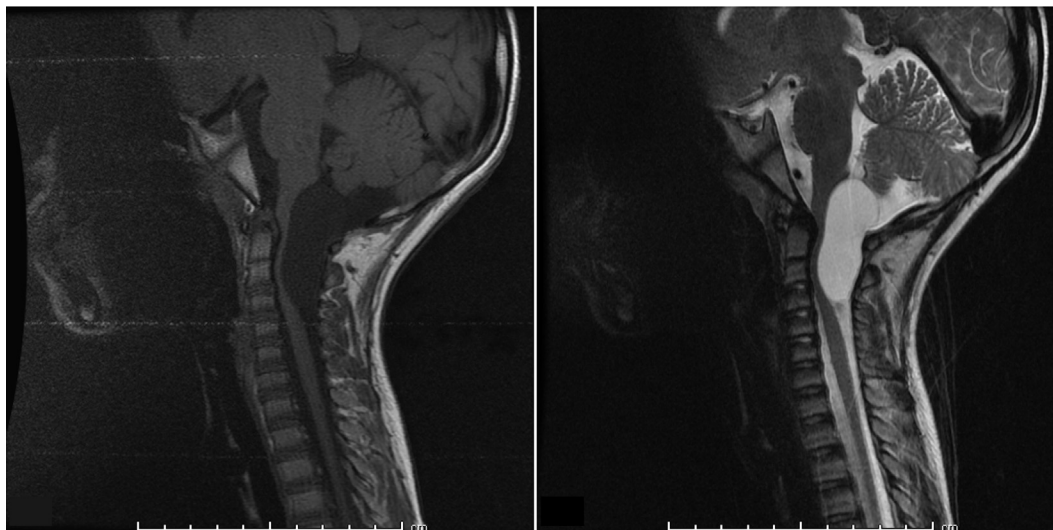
Sagittal T1 (left) and T2 (right) weighted magnetic resonance images showing a dorsally located cystic lesion extending from the level of the medulla oblongata to C3, that is hypointense in T1-weighted image and hyperintense in T2-weighted image.
